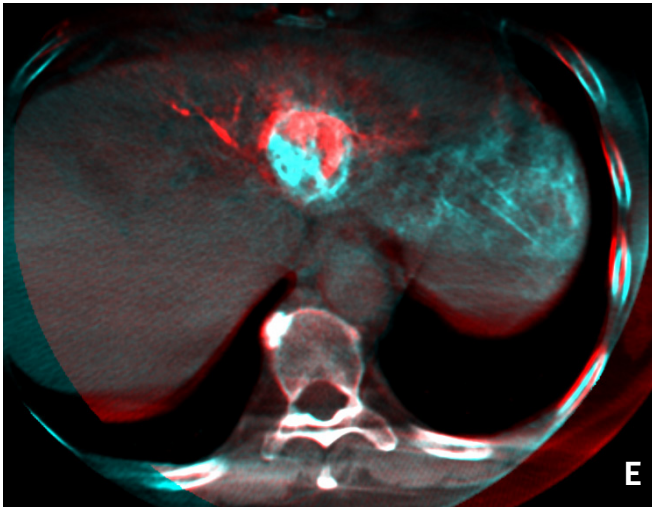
(continued) Fused CBCT images in (E) axial and (F) sagittal views showing complete supply of the tumor by segment 2 and 3 arteries, and mandating the injection of 2 separate Y-90 doses to treat the entire tumor. (G) 3D images reconstructed from the CBCT in Figure 1B showing the volume of the tumor (in blue) and the perfused area (in orange) supplied by the segment 2 artery. (H) 3D images reconstructed from the CBCT in Figure 1D showing the volume of the perfused area (in blue) supplied by the segment 3 artery.
